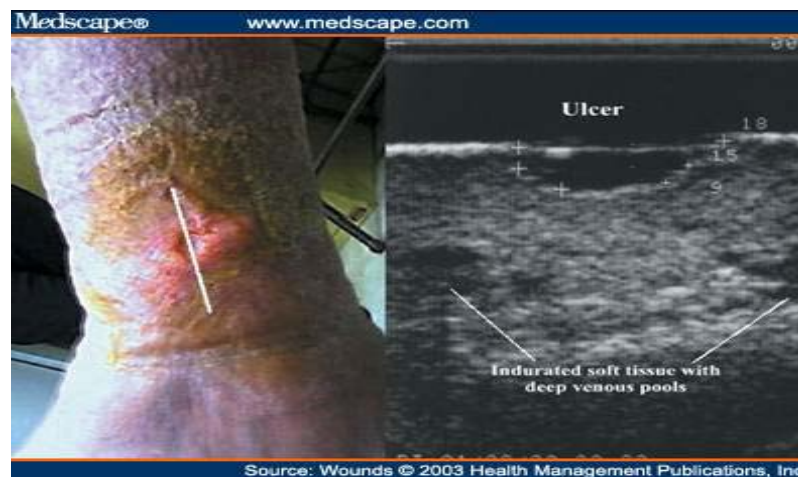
Venous ulcer (left) and its cross section scan using ultrasound (right) [Wendelken *et al.* 2003]
